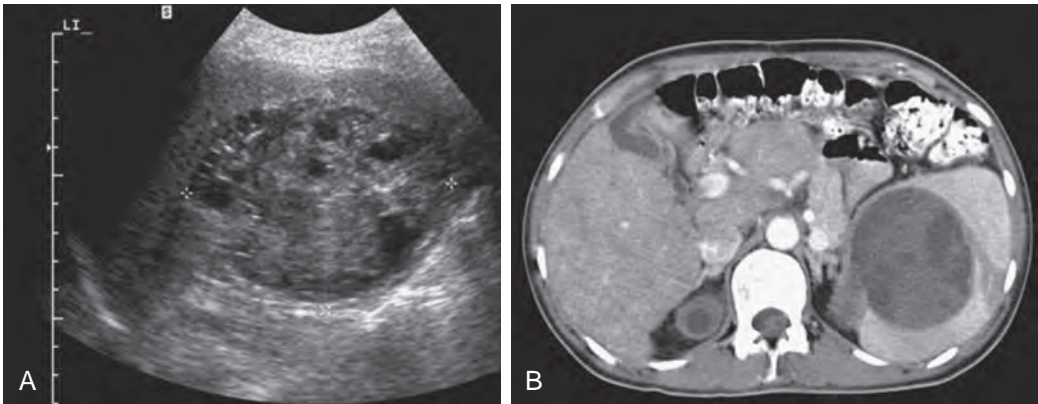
Echinococcal cyst: cystic echinococcosis type 3. A. Longitudinal ultrasound image of the spleen demonstrates a complex lesion with central hyperechoic areas and small peripheral daughter cysts. B. Contrast-enhanced CT during the arterial phase demonstrates an oval mass involving the medial portion of the spleen with relatively high central attenuation and a few peripheral hypodense daughter cysts. There is associated involvement of the right adrenal. (Courtesy M. de Jonge, MD, Amsterdam, The Netherlands.)
